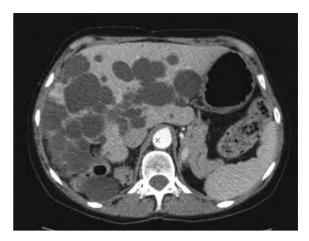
Axial CT scan image demonstrating multiple well-defined, round, uniformly fluid attenuation cysts in the liver of a patient with adult polycystic liver and kidney disease.
